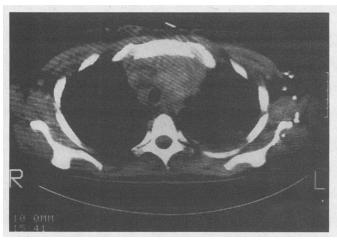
A chest computed tomographic scan in October 1987 shows prominent enlargement of the upper anterior mediastinum with diffuse replacement of fat by soft tissue density infiltrate. Also seen are dilated left chest wall collaterals.
